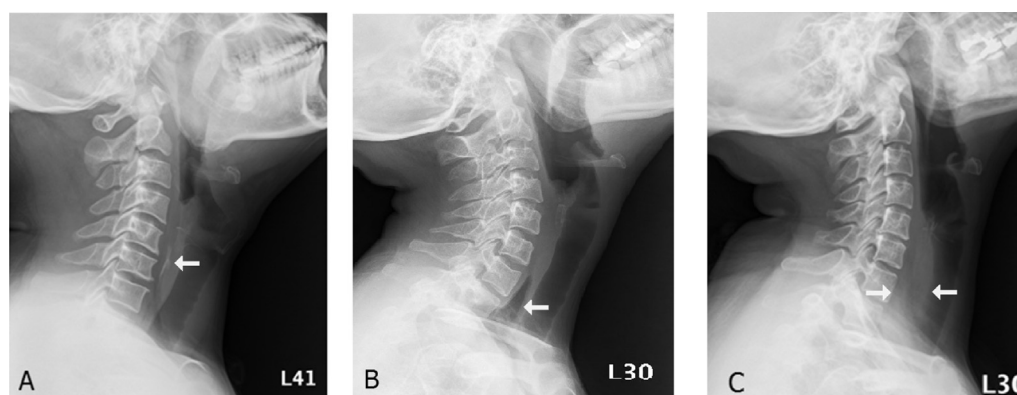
Different signs of esophageal foreign bodies in neck radiography (indicated by arrows). (A) linear opacity; (B) air-column; and (C) soft tissue swelling.
